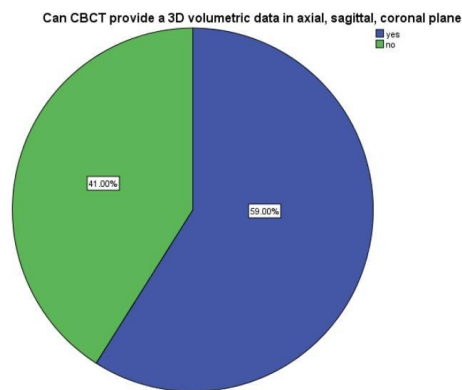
Pie chart shows the response about CBCT providing a 3D plane . 59 % said that it provides a 3D plane and 41% said it does not provide a 3-D plane. In this blue colour indicates yes and green colour indicates no.
